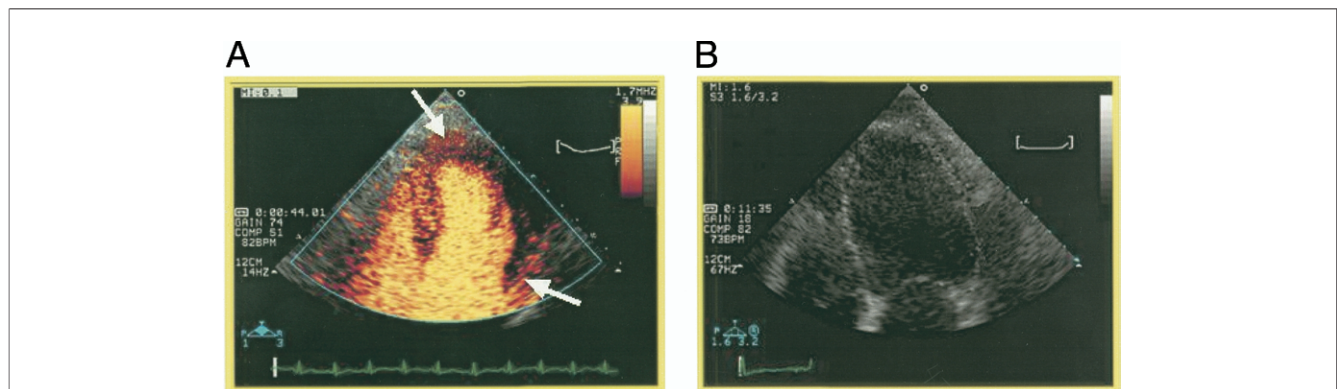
Example of Myocardial Contrast Echocardiography
